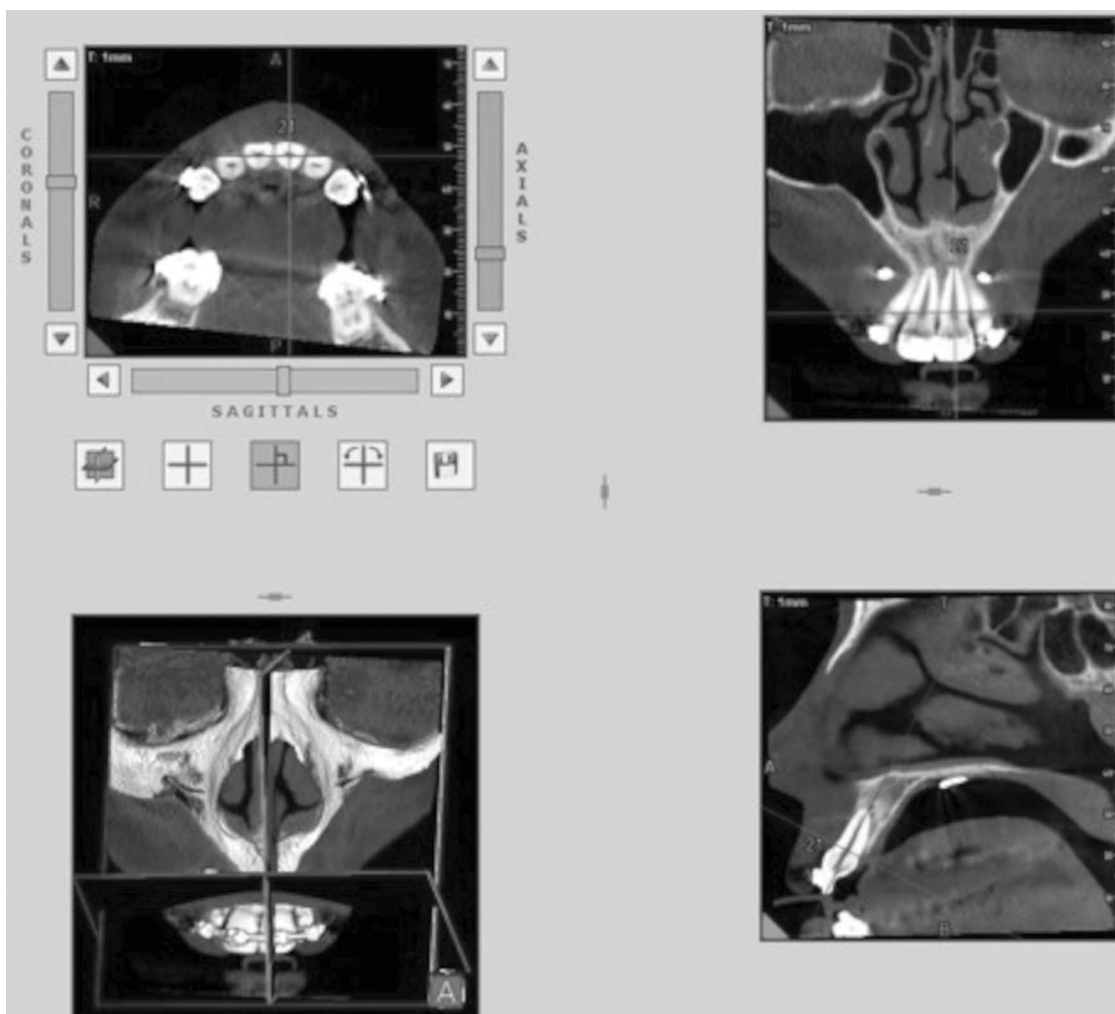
CBCT orientation of three planes of space.
